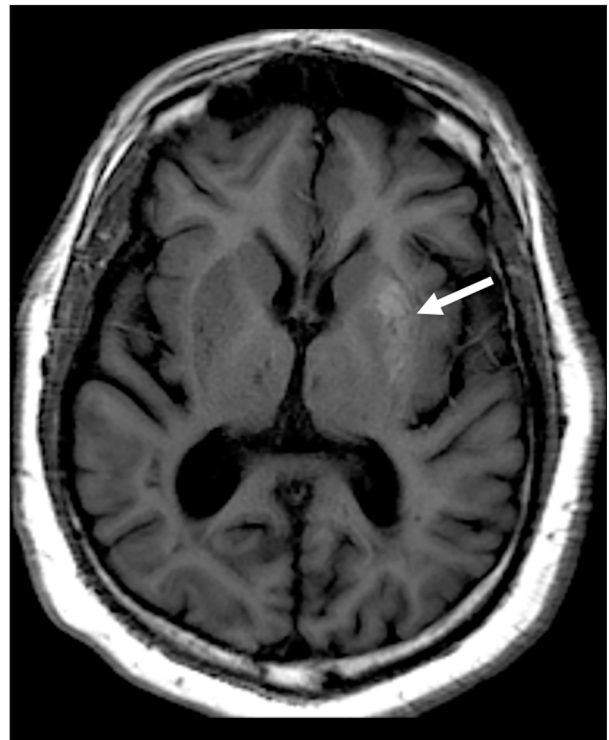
MRI head demonstrating diffuse T1 hyperintensity within the left lentiform nucleus (white arrow).
